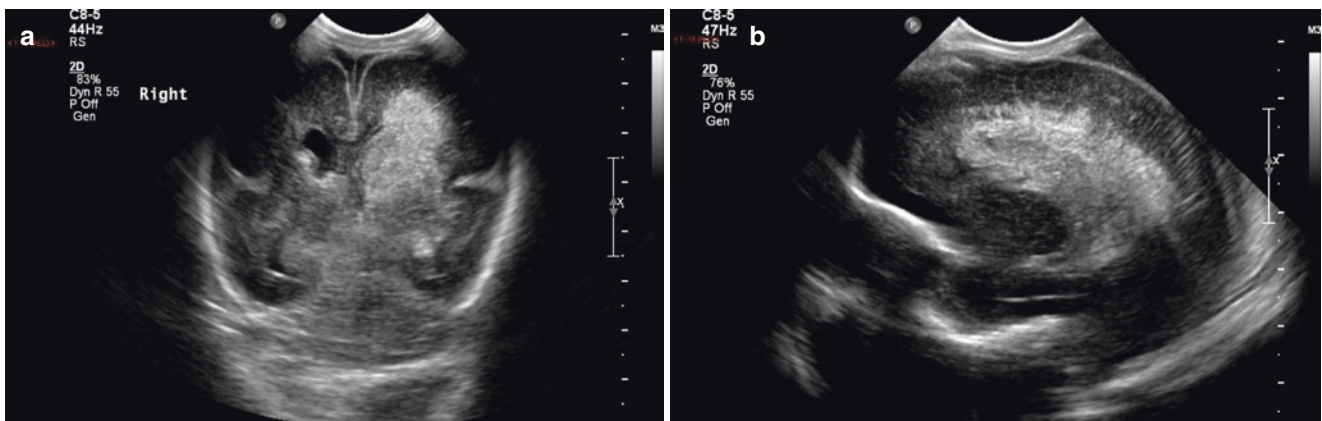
Grade 4 haemorrhage. Coronal (a) and parasagittal (b) ultrasound images show a large intraventricular haemorrhage within a dilated left lateral ventricle. There is also echogenic haemorrhage in the surrounding parenchyma, due to periventricular venous infarction
